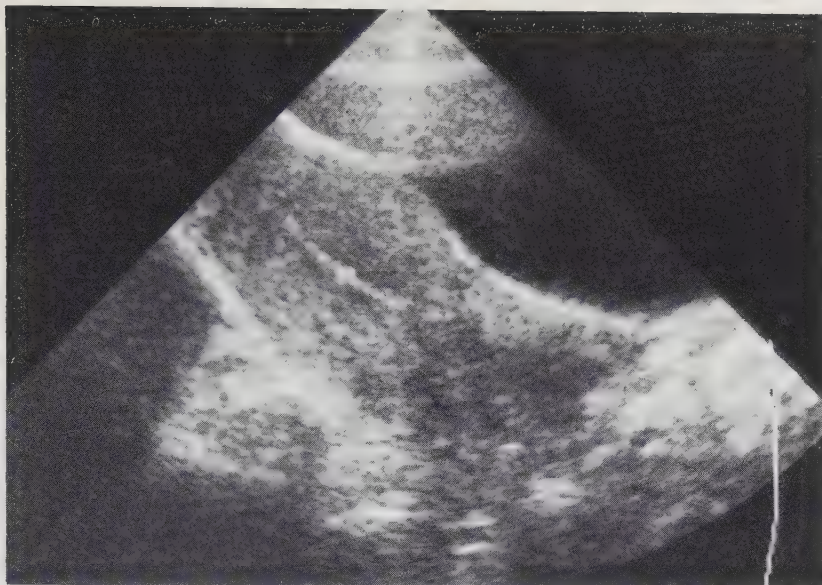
A typical representation of the endometrium by ultrasound of a woman who had used NORPLANT-2 since more than three years. The endometrial thickness in this woman was 12 mm.
